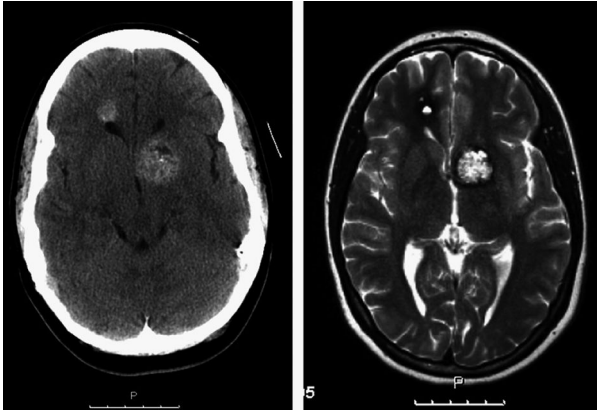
A left thalamic cavernoma can be seen on CT on the left and on T2-weighted MRI on the right. On MRI a typical dark ring can be seen corresponding to haemosiderin deposition caused by bleeding. A second right frontal lesion can also be seen. © Hugh Markus.
